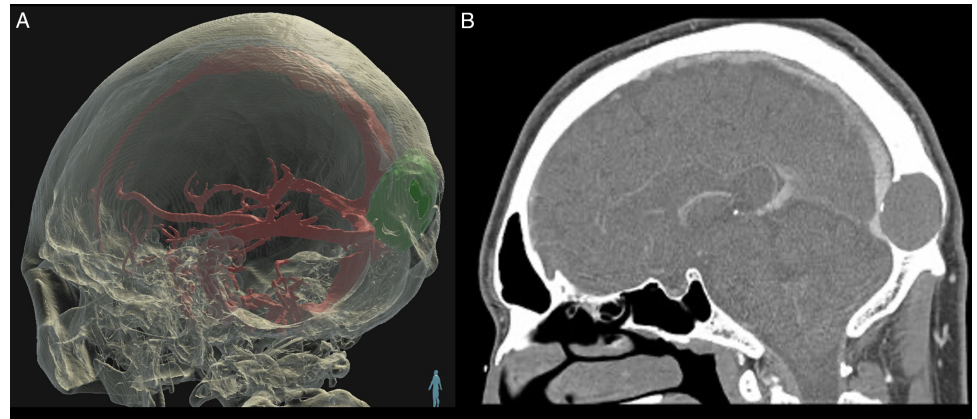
Virtual reality image (Elucis, Realize Medical Inc, Ottawa, Canada) showing a three-dimensional model of the occipital intradiploic epidermoid compressing the posterior one-third of the superior sagittal sinus and the torcula (a). These 3D anatomical models were generated from the accompanying sagittal CT venogram (b).
